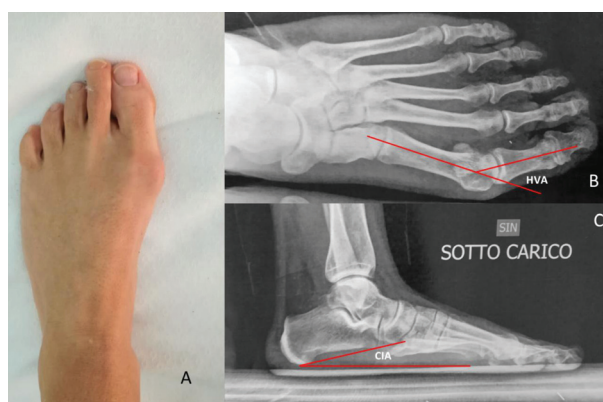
Pre-operative assessment of a 34-years old patient. A Pre-Operative Clinical photograph showing hallux valgus; B Pre-operative X-ray showing Hallux Valgus Angle (HVA) of 36° ; C Pre-operative X-ray showing Calcaneal Inclination Angle (CIA) of 12°
